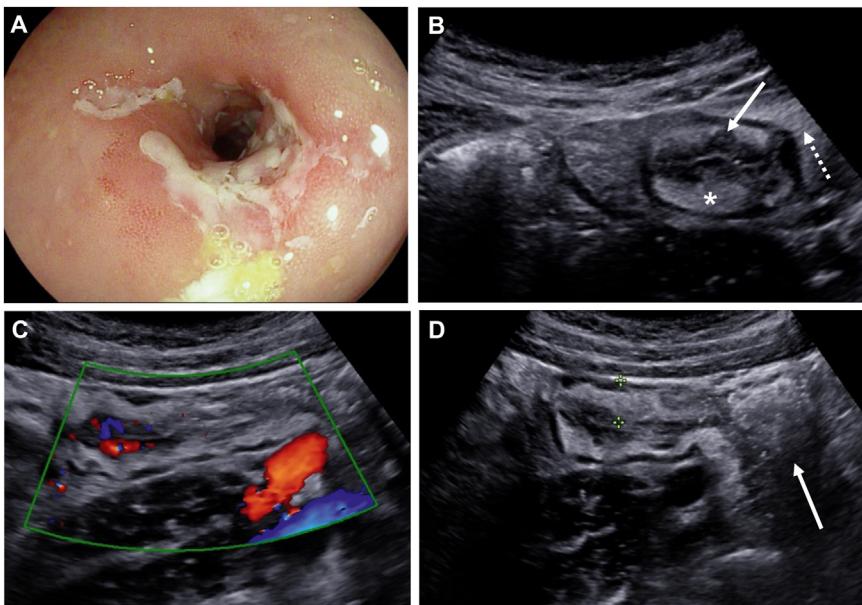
(A) Narrowed patulous ileocecal valve of patient with Crohn's disease. The endoscopist was unable to intubate the terminal ileum with a pediatric ileocolonoscope. Simple endoscopic score 11 (size of ulcers: 3, ulcerated surface: 3, affected surface: 2, narrowing cannot be passed with ileocolonoscopy: 3). Crohn's disease stricture on intestinal ultrasound. (B) Thickened Crohn's disease terminal ileum in cross-sectional view with echogenic thickened submucosa (asterisk), narrowed lumen, surrounding inflammatory fat (dashed arrow), and loss of echo stratification (arrow). (C) Longitudinal view of ileum with long chains of hyperemia with signals in perienteric fat (modified Limberg 3 color Doppler signal). (D) Longitudinal view of ileal stricture with thickened bowel wall (calipers), and prestenotic dilation with posterior wall shadowed by gas (arrow).
